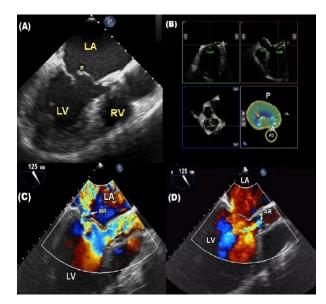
Flail mitral valve (FMV) and severe MR; A) The midesophageal two-chamber view of the mitral valve at 60 degrees revealed flail A2 scallop (yellow asterisk). B) Three-dimensional transesophageal echocardiography (TEE) using the multiplanar reconstruction (MPR) method confirmed flail A2 scallop (red arrow). C) Color Doppler TEE at 125 degrees showed severe MR (white arrow). D) Color Doppler TEE at 125 degrees showed moderate AR (white arrow). LA = left atrium; LV = left ventricle; RV = right ventricle; AV = aortic valve; MR = mitral regurgitation; AR = aortic regurgitation
